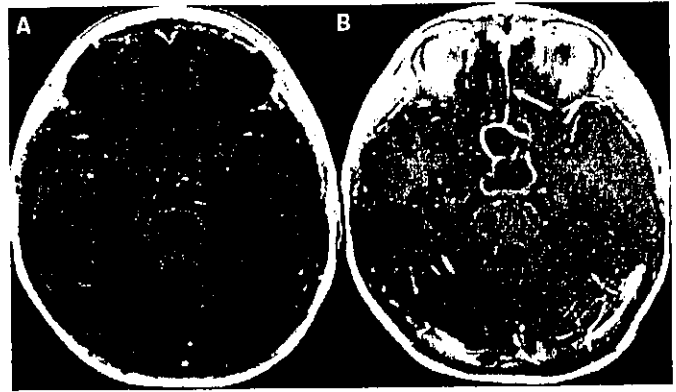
Axial T<sub>1</sub>-weighted gadolinium-enhanced (A) and coronal (B) MR images demonstrated a well-enhanced suprasellar mass extending to the third ventricle, and acute hydrocephalus. The mass measured 2.0 × 2.0 × 4.0 cm, with both solid and cystic components. The solid component was heterogeneously enhanced and included calcification. The cyst wall was well enhanced.
